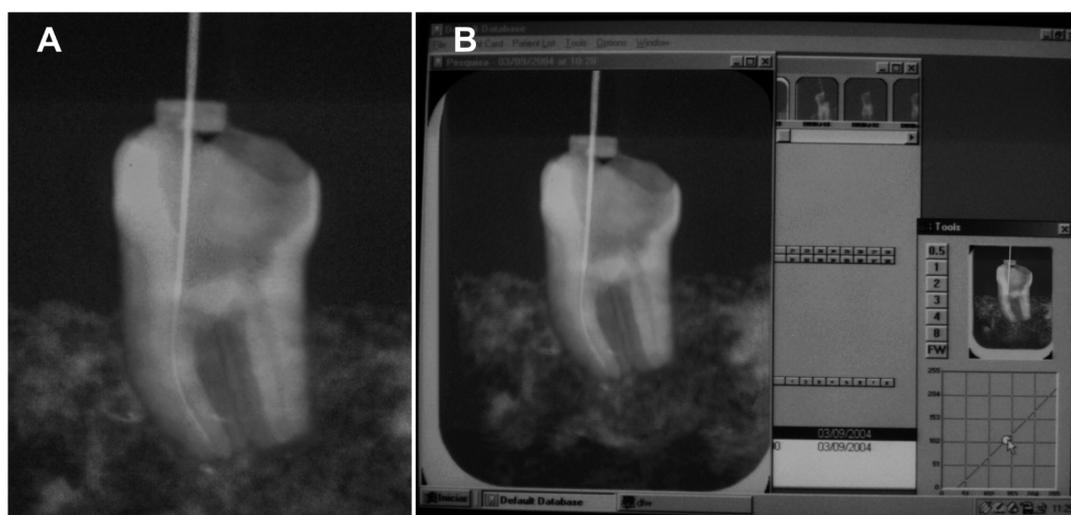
Examples of radiographic images. A: Conventional radiograph, B: Digital radiograph.
